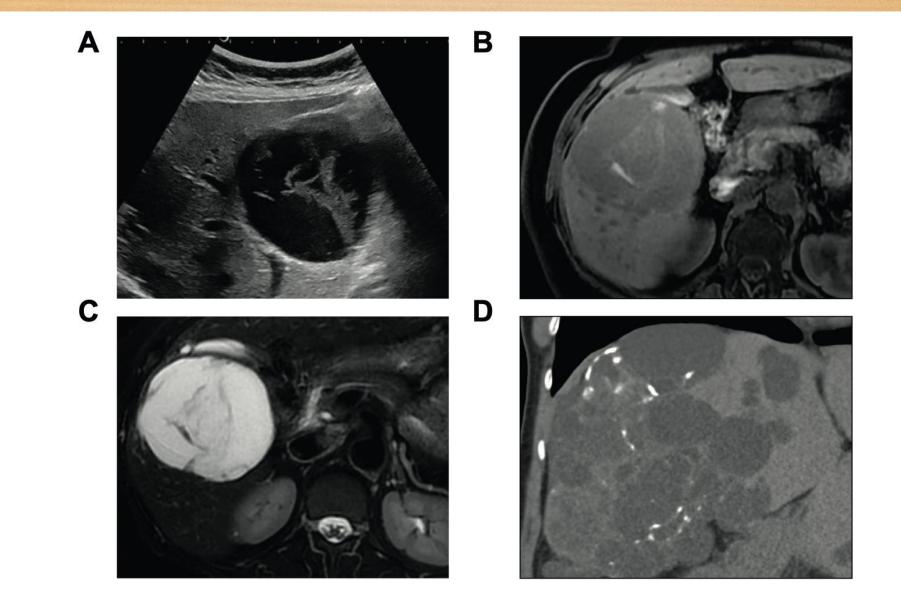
Haemorrhagic hepatic cyst and post-haemorrhage calcification. (A-C) haemorrhagic hepatic cyst. Ultrasound (panel A) shows a cystic lesion surrounded by a thin wall. Presence of multiple septations that do not enhance on contrast-enhanced ultrasound (not shown). On MRI (T1- and T2-weighted MRI) the lesion is strongly hyperintense on T2 and has intermediate signal on T1. Internal septations are strongly hyperintense on T1 and correspond to haemorrhagic septations. (D) Calcification after cyst haemorrhage.
